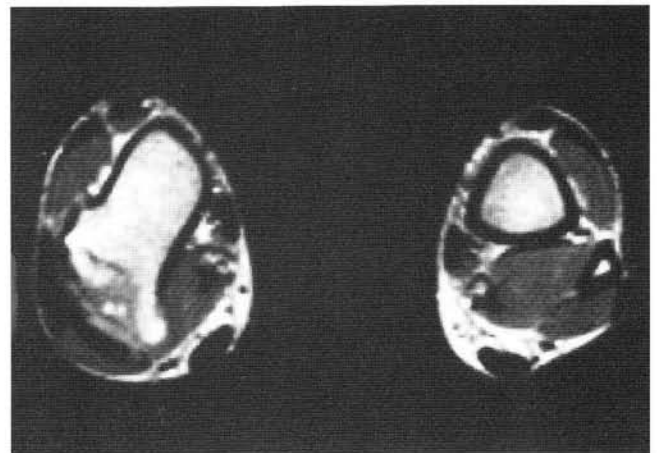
Transverse plane MRI showing the osteochondroma protruding from the posterior aspect of the tibia.
